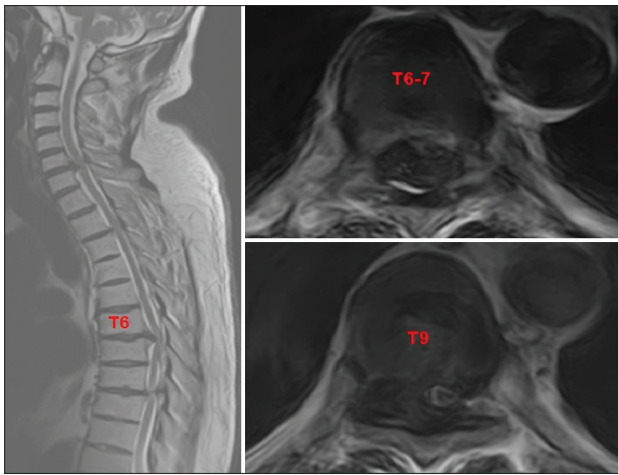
Sagittal T2 MR imaging of the spinal column: herniated discs at T6-7 and T8-9 with dural compression and myelopathy
